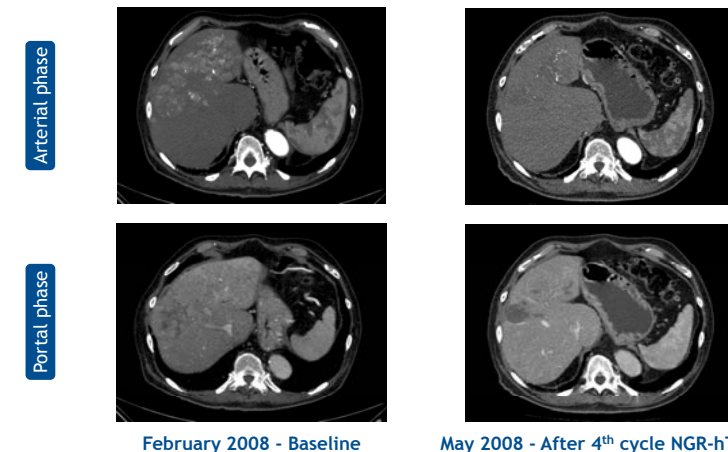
Complete necrosis in a hypervascular, infiltrating HCC after 4 cycles of NGR-hTNF evaluated by contrast-enhanced CT scan in a 76-year-old patient refractory to sorafenib
